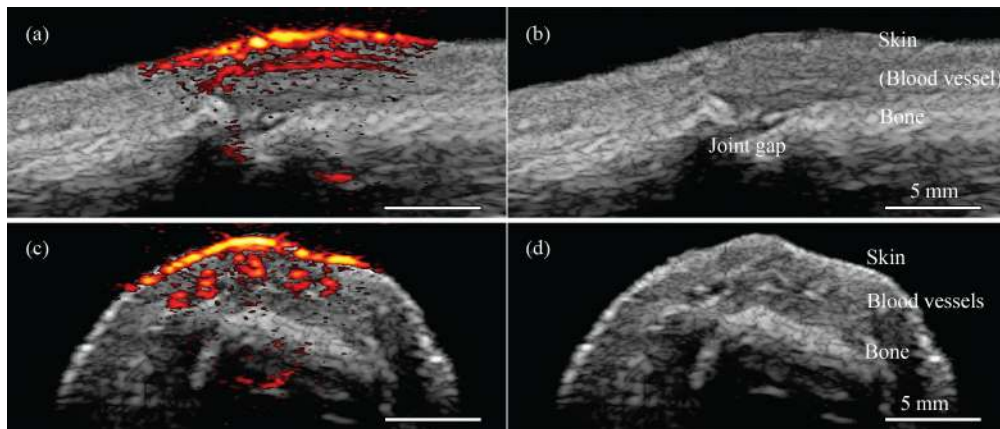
Photoacoustic/ultrasound images of a human proximal interphalangeal joint in sagittal (a) and transverse (b) planes, with the upper part of the image corresponding to the dorsal side of the finger. On the right side, (b) and (c) show corresponding ultrasound only with anatomical structures indicated.
